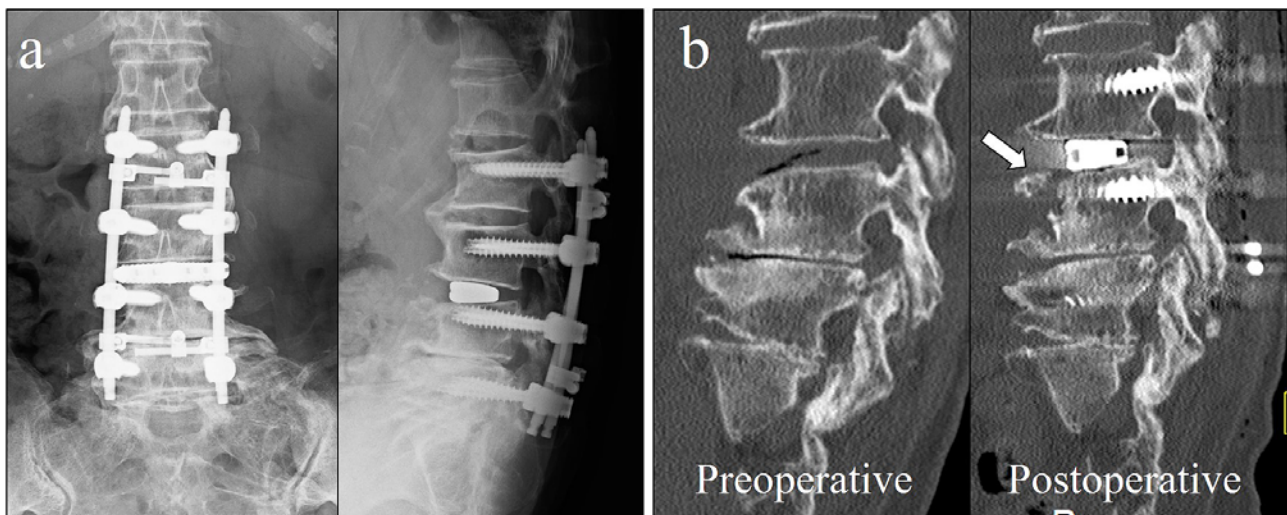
(a) Postoperative radiographs confirming that adequate compression was applied at L3/4 and that there was contact between the intervertebral cage and the endplate. (b) Preoperative and postoperative sagittal computed tomography images, with the postoperative image showing an avulsion fracture of the anterior longitudinal ligament (arrow).
